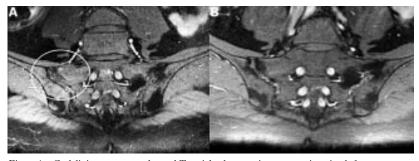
Gadolinium contrast enhanced  $T_1$  weighted magnetic resonance imaging before treatment with infliximab (A) showing contrast enhancement in the right ileosacral joint, and (B) in week 41 of treatment showing no contrast agent uptake.
